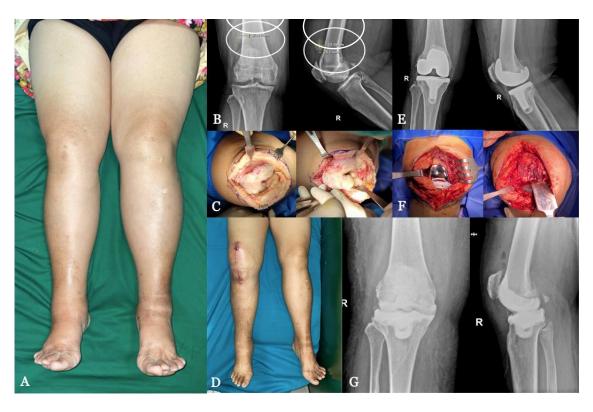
(A) Preoperative clinical presentation of the patient. (B) Preoperative knee X-ray revealing bony spurs in the suprapatellar recess. (C) Intraoperative exposure of the knee joint and removal of osteophytes. (D) Postrevision surgery knee clinical presentation. (E) Postrevision surgery knee clinical radiograph. (F) Intraoperative exposure of the knee implant and removal of the implant. (G) Postoperative knee X-ray depicting implant removal with bone spacer augmentation.
